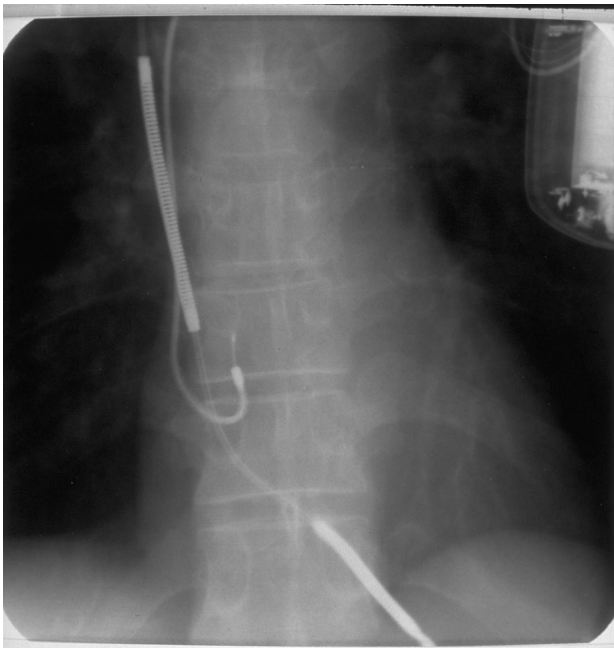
X-ray of an implanted PHYLAX AV.
